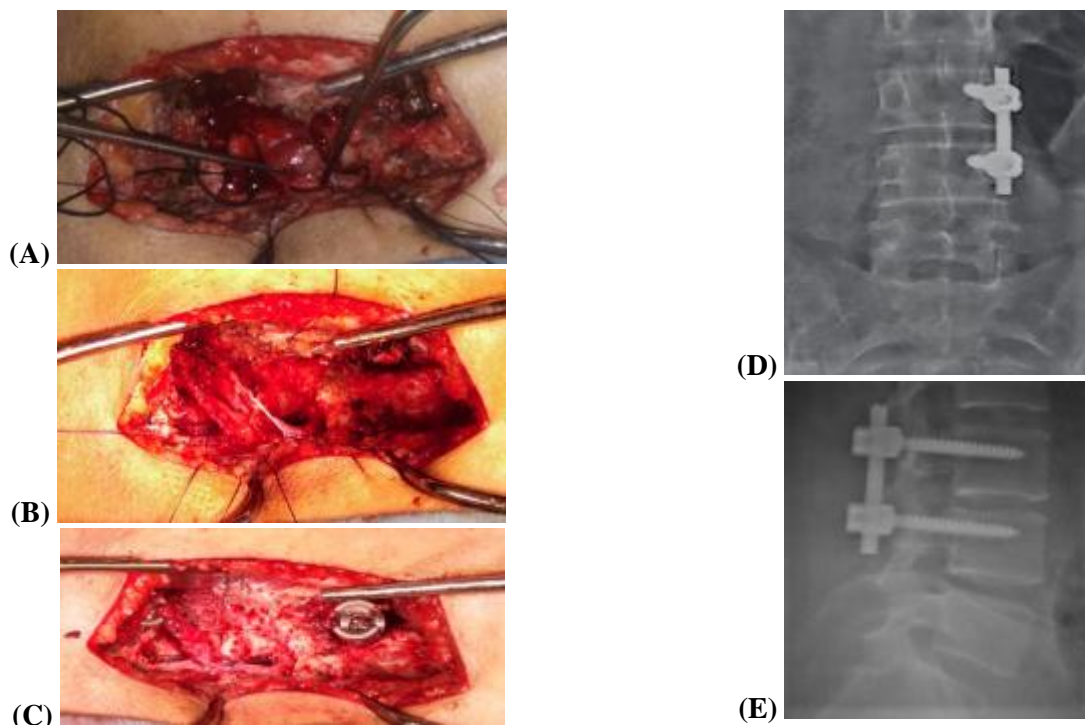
A case of intradural extramedullary mass towards the left side of the dural sac opposite L3 level and extending through the neural foramen at L3, L4 level. A patient 32 years old, presented with severe radicular pain and LBP (VAS 10) with no weakness. Left hemilaminectomy was done and the neural foramen was deroofted, dural opening done at lateral side and extended through the L3 root, complete excision was done and unilateral pedicle instrumentation. Postoperatively her pain subsided completely (VAS 0). A, B, C: intra-operative tumor excision and dural repair D&E: post-operative X-ray.
